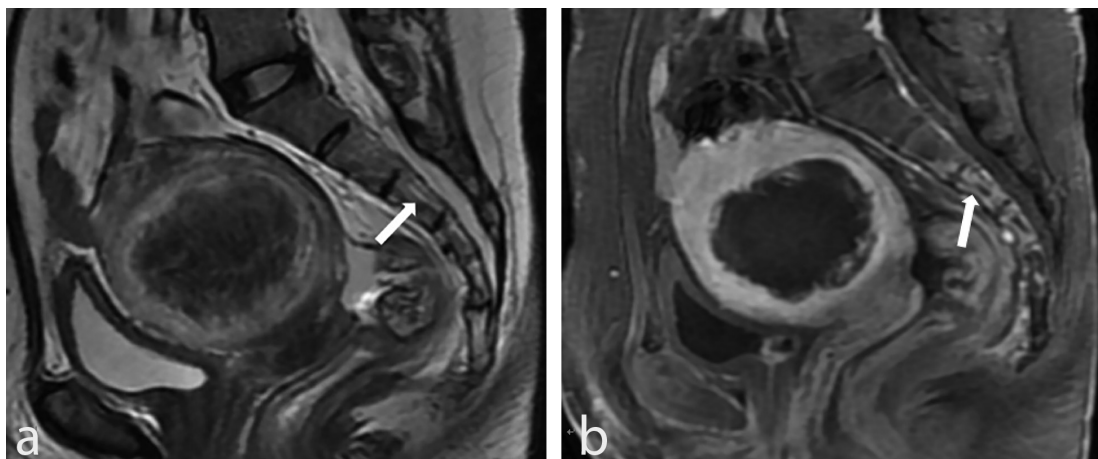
Sacral injury: sagittal view of MRI results obtained from a 44-year-old patient with uterine fibroids after high-intensity focused ultrasound showed normal morphology and structure in the sacrum. (a) The postoperative T2WI showed a strip-shaped high signal intensity of the 2nd–4th cones in the sacrum (arrow). (b) The postoperative contrast-enhanced MRI showed a slightly enhanced strip-shaped high signal intensity (arrow). MRI, magnetic resonance imaging.
